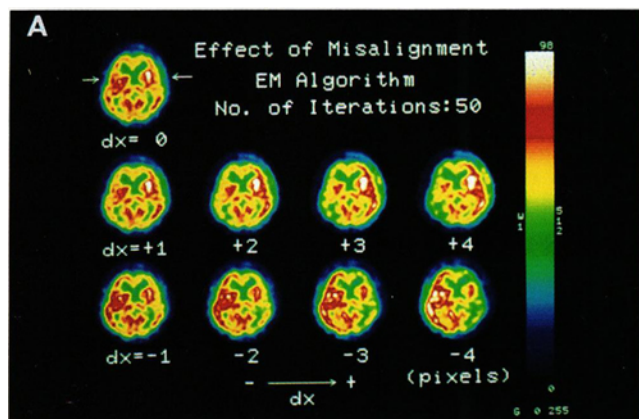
(A) Reconstructed SPECT images as a function of horizontal shift (dx) in the clinical study. The numbers show the horizontal shift in pixels. (B) Changes in image profile due to misalignment in the horizontal direction. Position of the profile is shown by arrows in the upper left image in (A). The effect of a horizontal shift (dx) of 0, +2, and -2 pixels is shown. — : $dx = 0$ pixels, ---- : $dx = +2$ pixels, and - - - : $dx = -2$ pixels.
